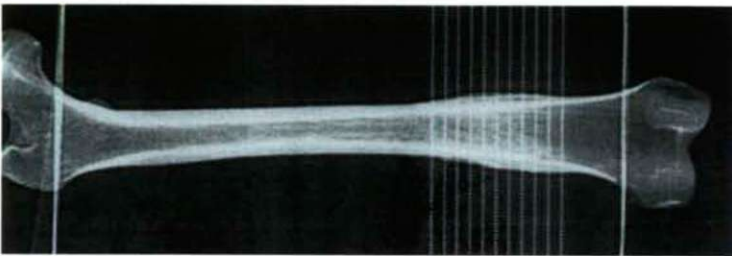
CT analysis of the right femur (CT by M. PANUEL).
